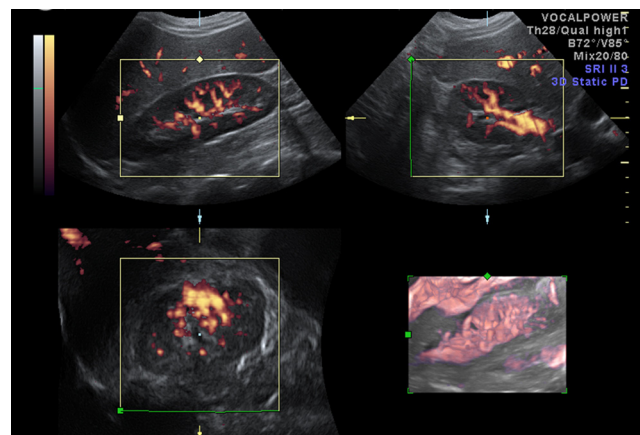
Sonogram showing 3D power Doppler acquisition in the longitudinal view by 3D power Doppler ultrasound. The power Doppler box positioned to cover the whole kidney. The widest scanning angle (85°) including the entire kidney was used.
